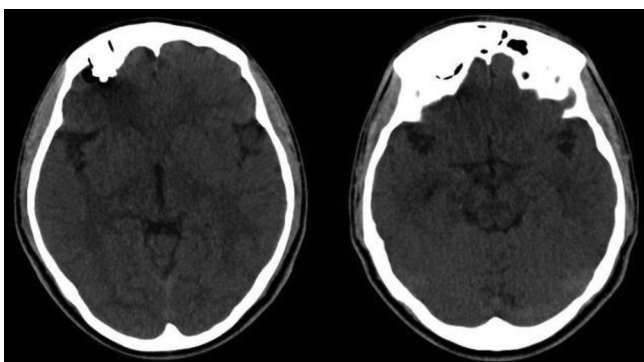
Axial non contrast CT scan of the head in brain parenchyma window settings. The scan shows large pneumocephalus noted in the right frontal region with displacement of the right frontal cortex. No midline shift. No parenchymal edema.
